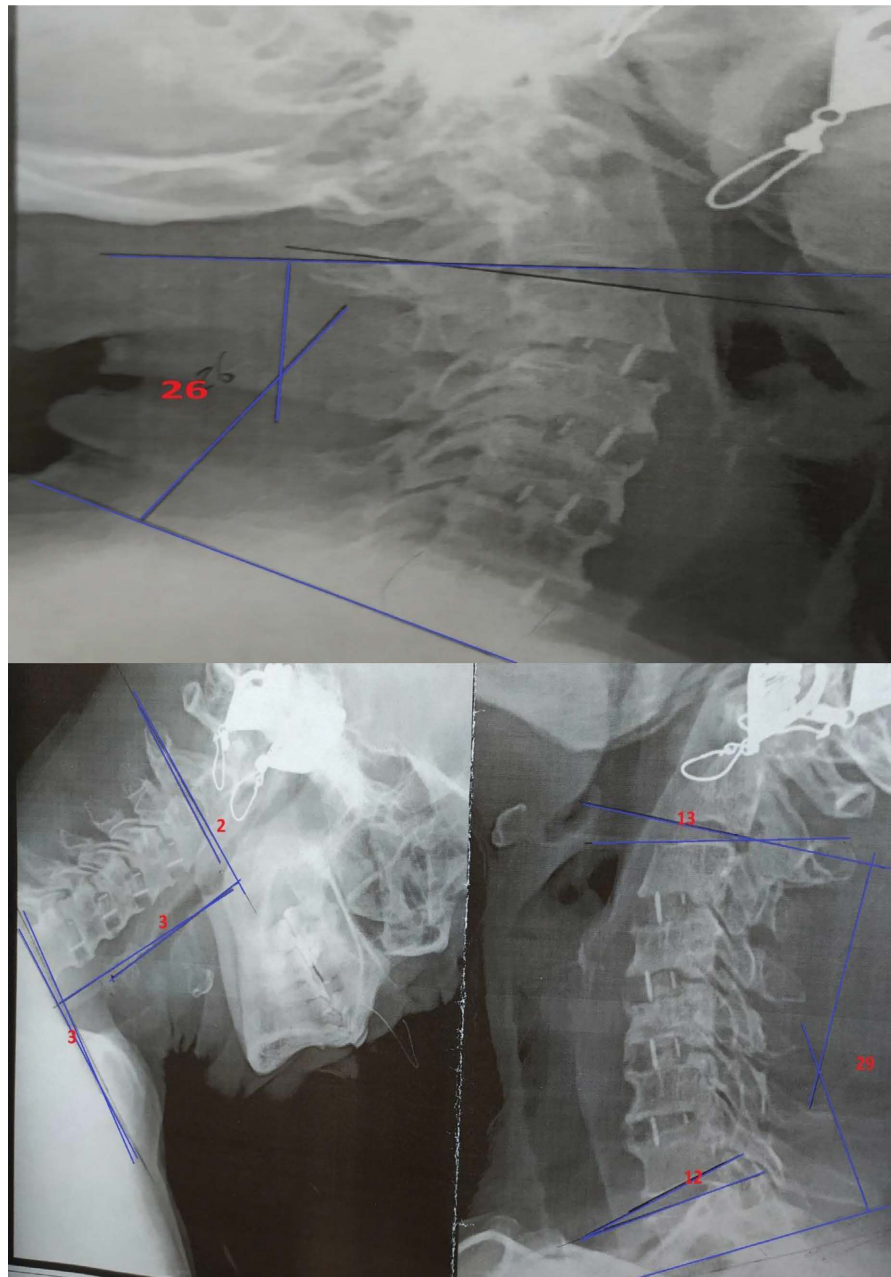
1 month Postoperative X-ray Cervical spine flexion, extension and lateral views of the previous patient operated upon by 4 level ACDF showed global lordosis was 26 and global ROM reduced to 32 (29 for extension and 3 for flexion). Cranial ROM decreased to 15 (13 in extension and 2 in flexion).
